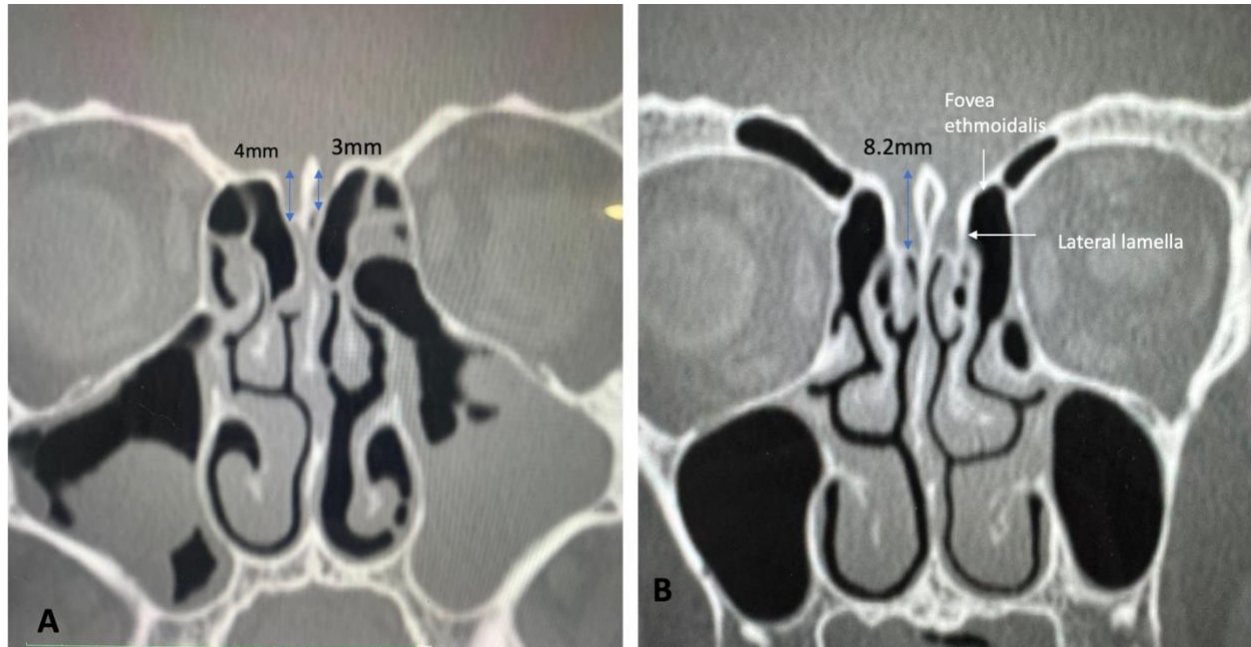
CT scan coronal plane for two distinctive patients: patient (A) displays Keros type I on the left side and Keros type II on the right side. (B) Another patient with Keros type III on the right side.
